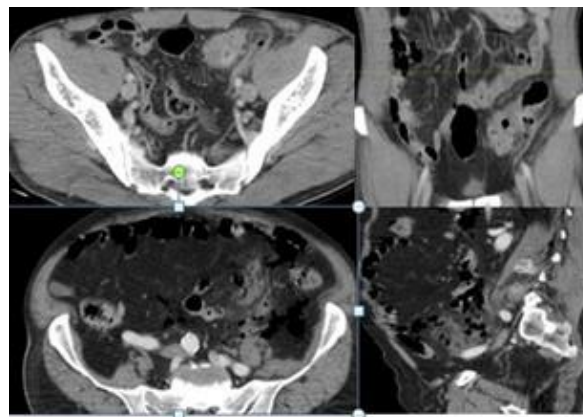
Abdominal CT. 53-year-old male patient with Hincheys III. (a) Axial and reformatted images. Phlegmon, intramural focal abscess, and peritonitis are observed in the sigmoid colon. In the abdominal CT axial images taken due to the patient having a new episode one year after being discharged from a six-day stay at the hospital receiving conservative treatment, phlegmon and perforation is observed in a longer segment. The disease progressed to Hincheys IV. (b) Abdominal CT. 80-year-old male patient with Hincheys IV. Axial and sagittal reformatted images. Phlegmon, pelvic abscess, peritonitis, generalized free air, and perforation are observed in the sigmoid colon. Segmental resection was performed, and the patient was discharged after 21 days.
